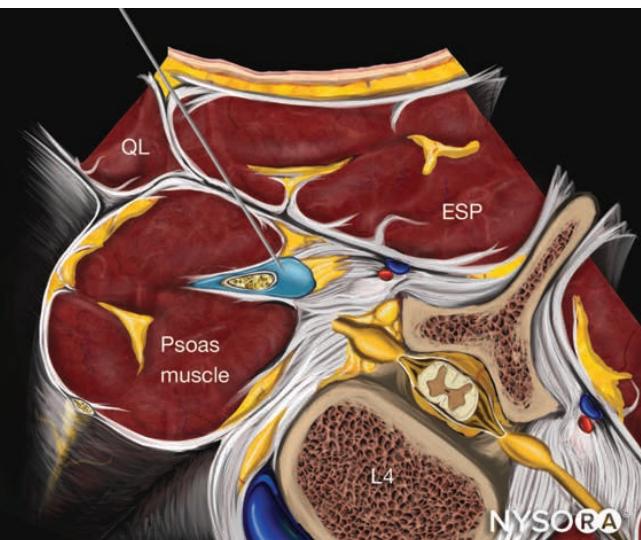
Reverse ultrasound anatomy of a lumbar plexus block using the transverse oblique approach. QL, quadratus lumborum; ESP, erector spinae muscles.
